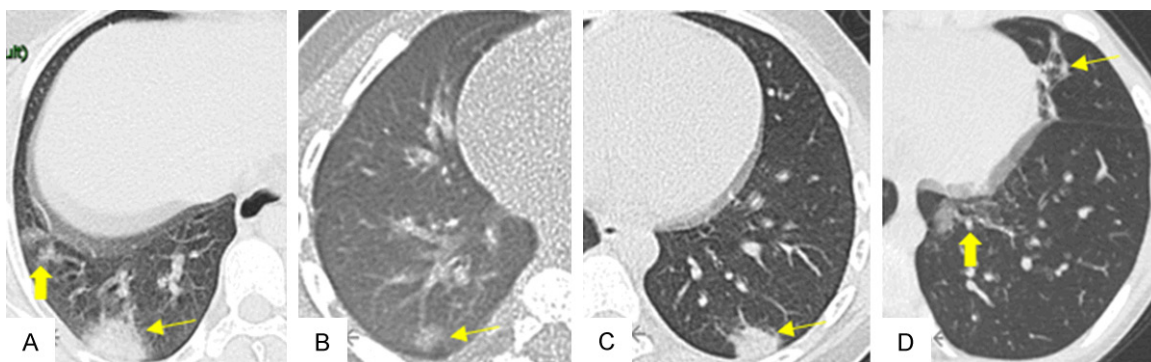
Chest CT findings of infants and children with COVID-19 infection. A: Mixed GGO (thick arrow) and consolidation (thin arrow). B: GGO (thin arrow). C: Consolidation (thin arrow). D: Patchy (thick arrow) and streaky (thin arrow) shadows.
